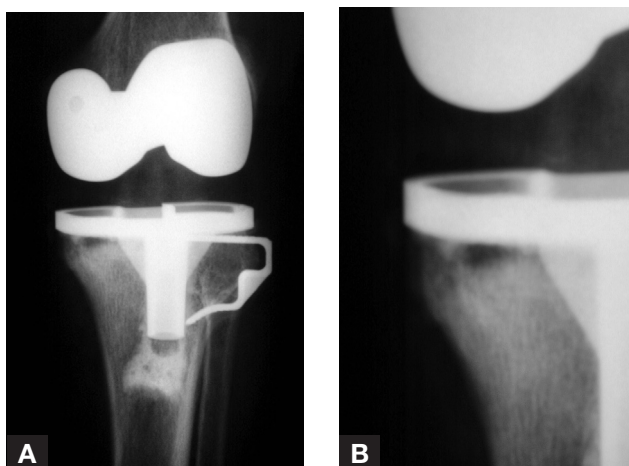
Case 1. (A) Anteroposterior radiograph shows radiolucency under medial tibial baseplate and interval progression of osteonecrotic lesion in lateral proximal tibial metaphysis. (B) Medial tibial radiolucent region, magnified.
